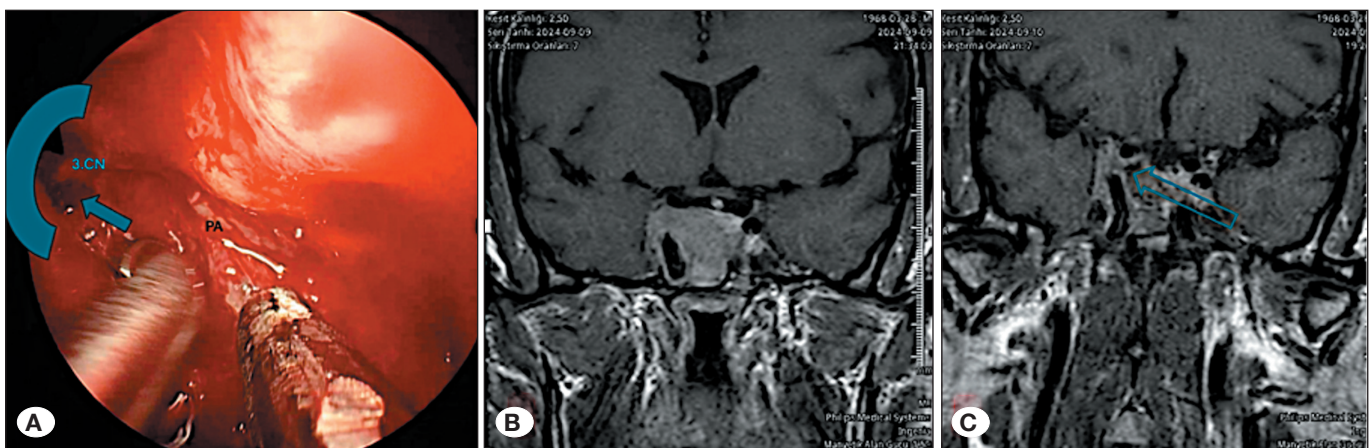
A) The thick C-shaped structure represents the internal carotid artery siphon (C4). The arrow points to the medial corridor (MC), whose lateral boundary is the third cranial nerve (3rd CN). B) Preoperative magnetic resonance imaging (MRI) demonstrating tumor extension into the medial corridor. C) Postoperative MRI confirming gross total resection of the tumor. PA: pituitary adenoma.
